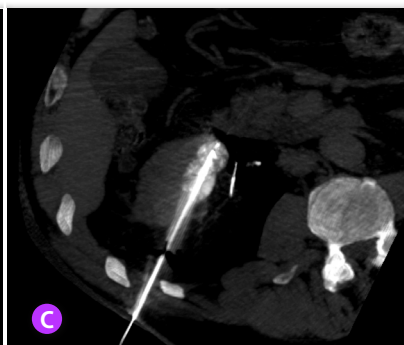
CT (axial plane) shows an IceSphere™ 1.5 needle inserted into the upper pole of the renal tumour
